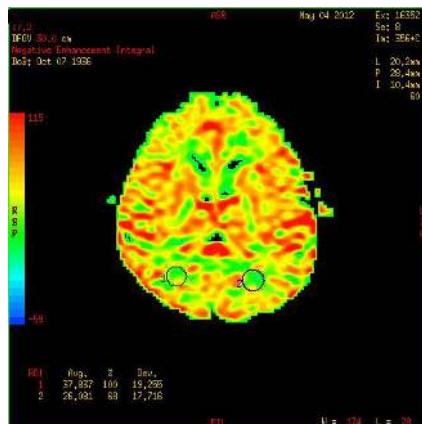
Regional cerebral flow distribution map produced by MRI perfusion sequence
